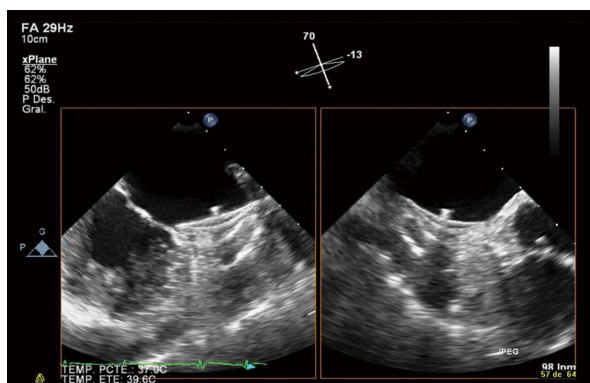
Forty-five day control. Transesophageal echocardiography two-dimensional X-plane processing, simultaneous visualization at 70° (left) and 13° (right). Successful Amplatzer™ cardiac plug implantation: completely covering the left atrial appendage ostium by the occluder disk and no evidence of device thrombosis.
